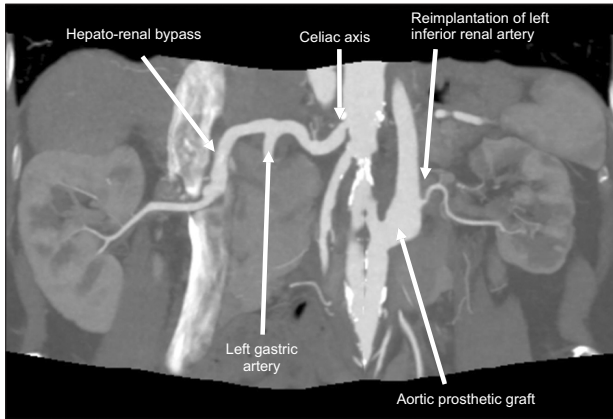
Reconstructed computed tomography angiography showed the both renal artery revascularization; right hepato-renal bypass and left inferior renal artery reimplantation.
